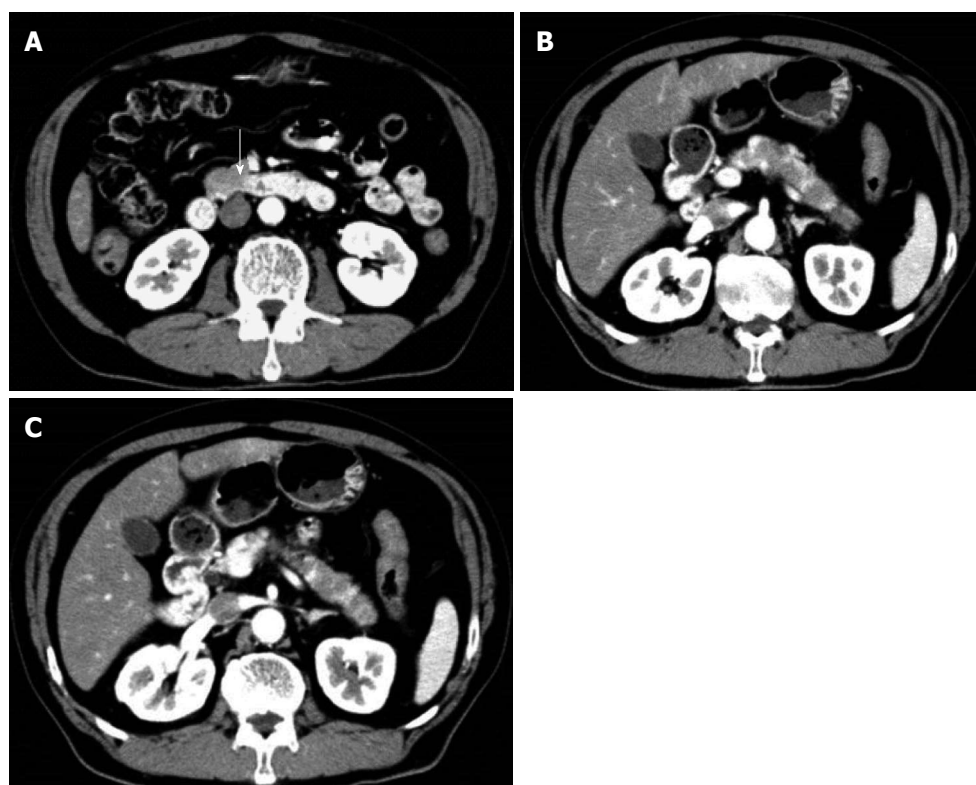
Contrast-enhanced abdominal/pelvic computed tomography showing pancreatic enlargement with a diffuse, poorly enhanced area in the uncinate process (arrow) and pancreatic body tail (A-C).
